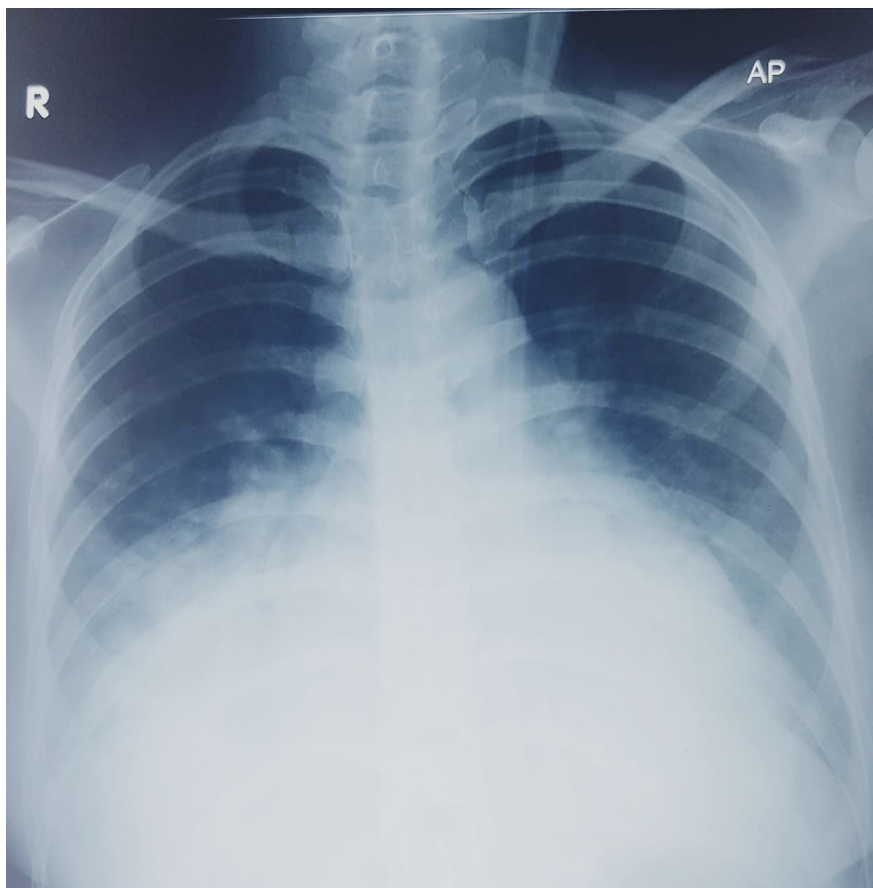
Chest X-Ray on admission showing cardiomegaly, bilateral pleural effusion, right paracardial infiltrate, and early lung edema.
